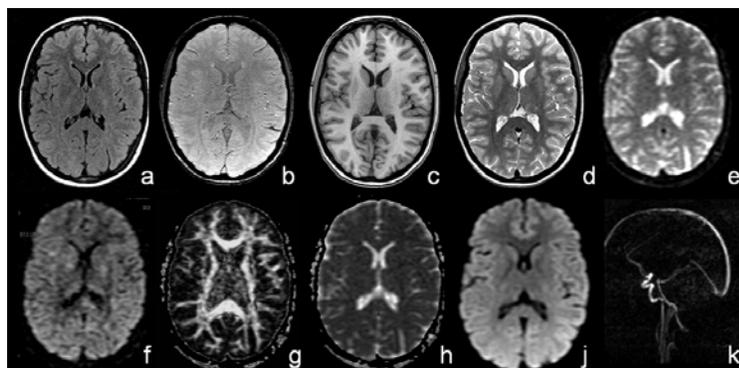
3D data sets collected on an 80 year old volunteer providing coverage of the entire brain with thin slices and high in-plane spatial resolution (a) 2D FLAIR TR/TE/TI=8000/122/2000 ms, (b) 3D SWI TR/TE=45/31 ms, (c) 3D T1W TR/TE/TI=13.8/2.8/400 ms, (d) PDW TR/TE=12300/17 ms, (e) T2W EPI $-b=0 \text{ mm}^2/\text{s}$, (f) DWI tensor $b=1000 \text{ mm}^2/\text{s}$, (g) fractional anisotropy, (h) diffusion map, (i) isotropic diffusion (k) flow scout for brain global blood flow. The finer sensitivity of FLAIR is used to identify white matter lesions while the other data sets complement showing white matter lesions as white spots in white matter regions. Analysis of all these datasets shall provide a better understanding on how lesions develop in the aging brain and provide a setup in which automatic processing be performed to separate all the different tissues in the brain. The in-plane resolution of the morphological scans was $0.60 \times 1.0 \text{ mm}^2$, number of slices and thicknesses as denoted in Table 1.
